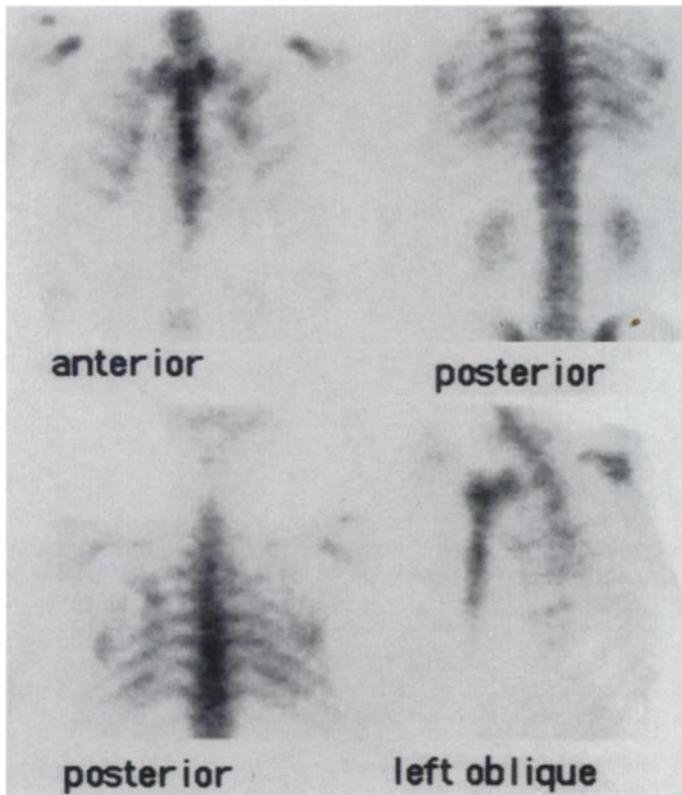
Repeat bone scan 2 mo later. No osseous or extraosseous abnormalities could be seen. The scintigram was judged as normal.
